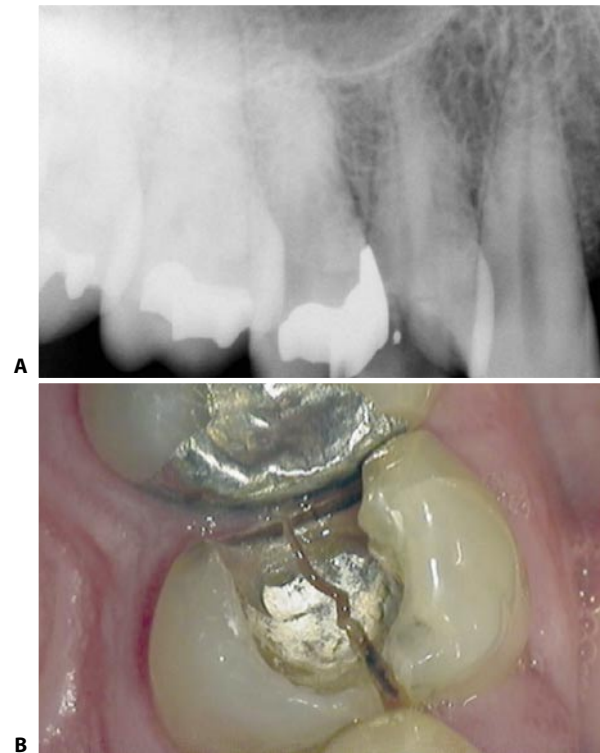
A. Preoperative radiograph of the first upper premolar. B. Clinical view showing the deep fracture: the tooth has been extracted.
